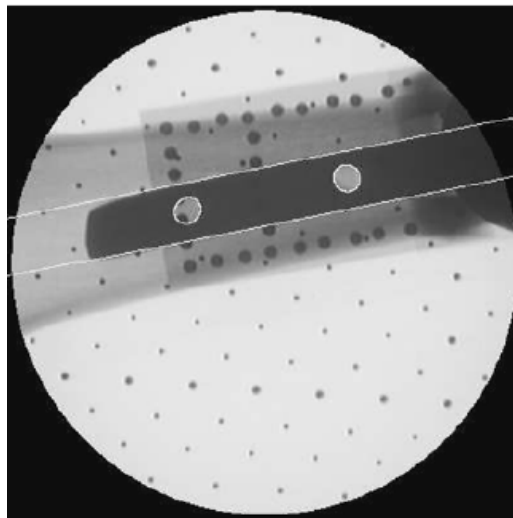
Detected nail's longitudinal contour (white lines) in fluoroscopic X-ray image [YJ05].
